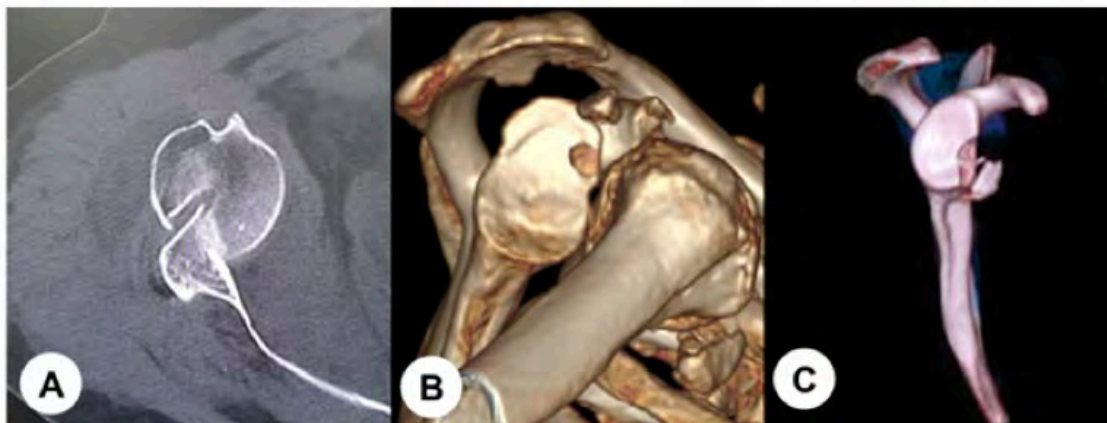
Computed tomography of shoulder dislocation. (A) Axial image, and three dimensional reconstruction images in (B) anterior dislocation and (C) bony Bankart lesion.
